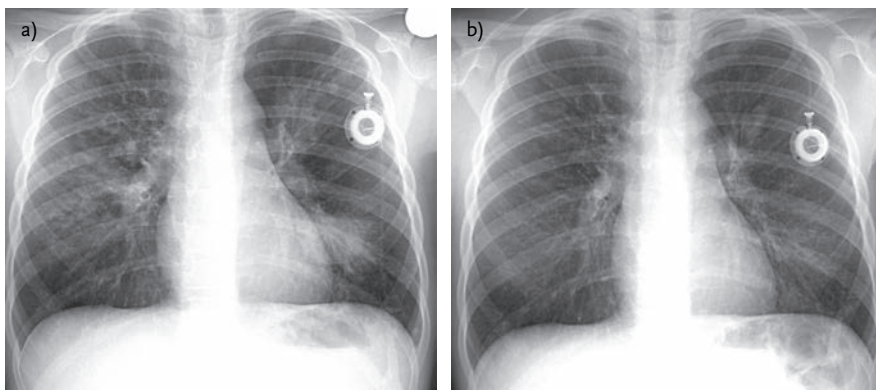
Chest radiograph from a CF patient recently diagnosed with ABPA. a) A combination of widespread indistinct nodular opacities, ring shadows (bronchiectatic airways) in the right mid zone, and consolidation in the left lower lobe can be seen. b) Several months later, most of the shadowing has resolved but there is a new elliptical opacity (a plugged bronchiectatic airway) just above the left hilum.
